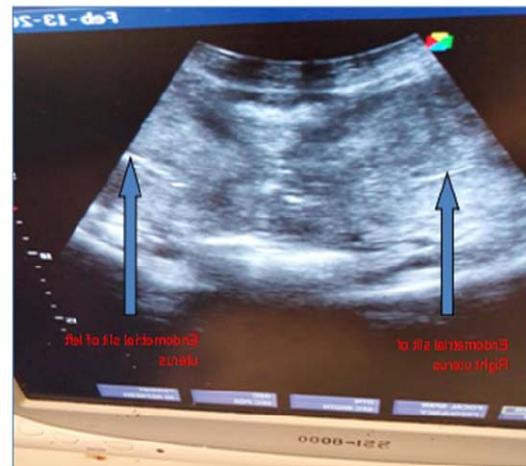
postoperative sonographic image of didelphys showing two endometrial slit.
